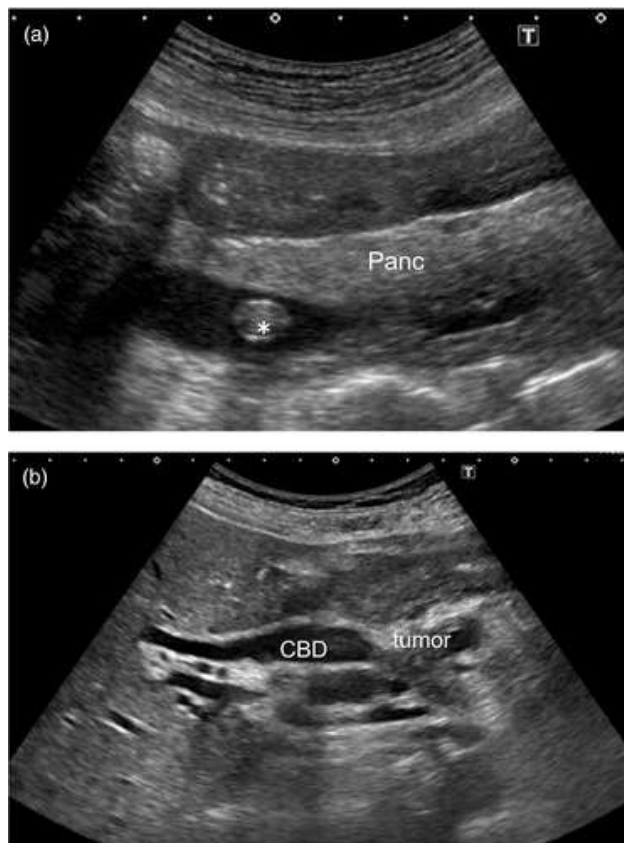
Abdominal Ultrasound (a) Gallbladder stones are visible as hyperechoic nodules with minimal acoustic shadowing within the intrapancreatic bile duct. (b) Cholangitis caused by pancreatic head cancer. The bile duct is clearly dilated and obstructed by a pancreatic head tumor. (Kiryama et al, 2018)
